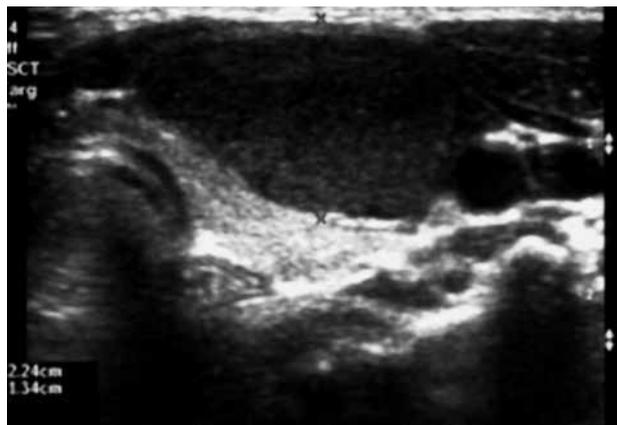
Ultrasound of intrathyroid lesion.
